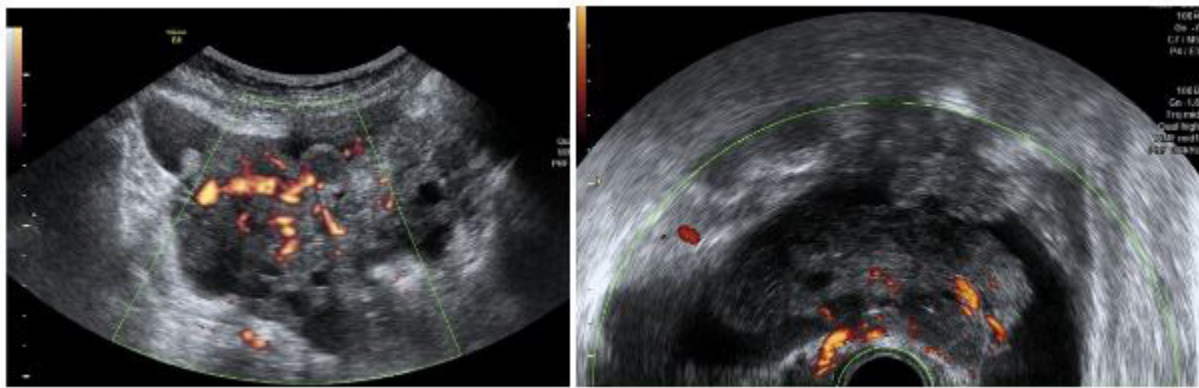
The right ovarian shows a solid and heterogeneous 93 x 32 mm tumour presenting vascularisation in the Doppler study (score 4). The left ovarian shows a solid and heterogeneous 83 x 54 mm tumour presenting vascularisation in the Doppler study (score 4).
